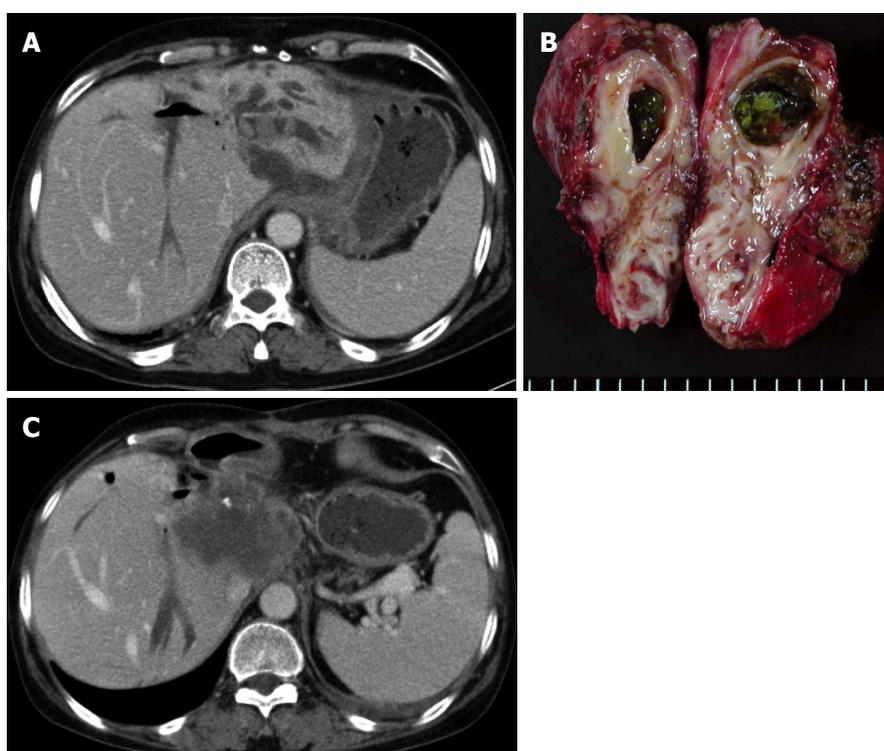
Forty-six years old, female was admitted for cholangitis. A: Abdominal CT demonstrated that multiple calcified stones are present in the lateral segment of the left lobe; B: Liver, left lobectomy was performed, and there was no cancerous lesion; C: Abdominal computed tomography taken 14 mo after resection demonstrated development of cholangiocarcinoma in the caudate lobe of the liver.
